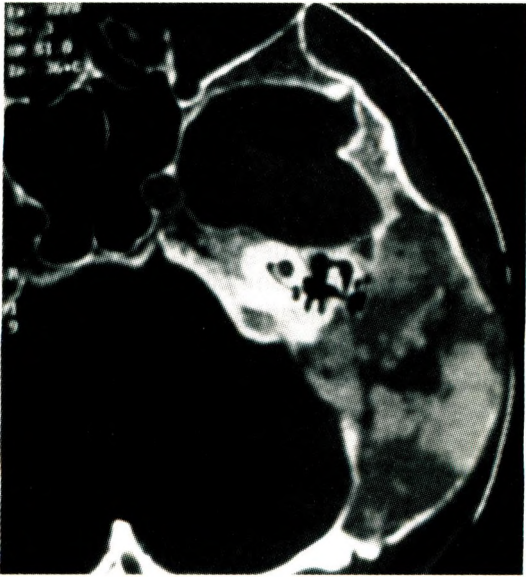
Axial section of the temporal bone CT. It is in pagetoid type.
